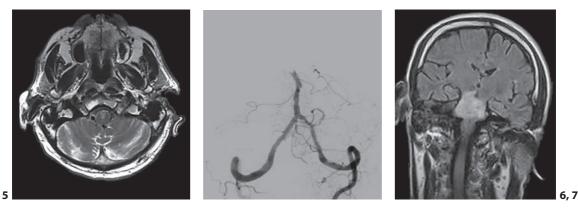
MRI T₂W bulbar lesion in a locked-in patient.
